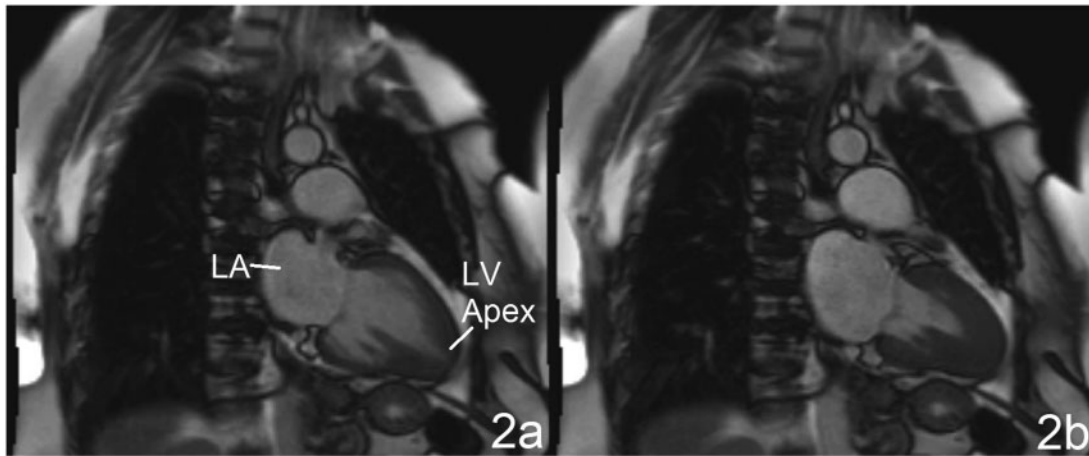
Cardiac magnetic resonance imaging cine two-chamber views in diastole (A) and systole (B) with where the apical hypertrophy clearly contrasts with the normal wall thickness seen throughout the rest of the left ventricle. Also note the left atrial enlargement.
